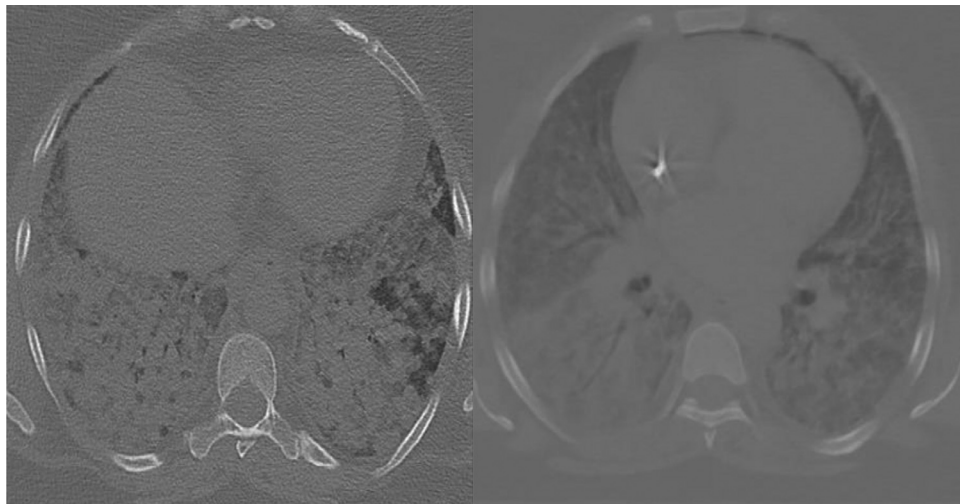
CT scan of the lungs showed the progression of lung lesions and were highly recommend of COVID-19 pneumonia within 72 hours later.
